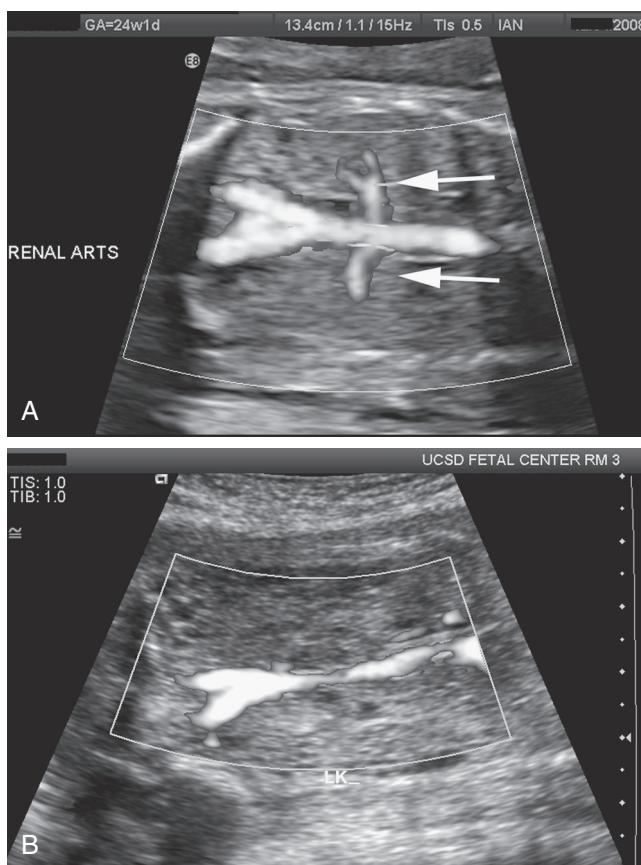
Bilateral renal agenesis. A, Doppler image of normal renal arteries (arrows) at 24 weeks' gestation. B, Power Doppler image of fetal abdominal aorta and its bifurcation at 20 weeks' gestation, demonstrating bilateral absence of renal arteries. Note absence of amniotic fluid.
